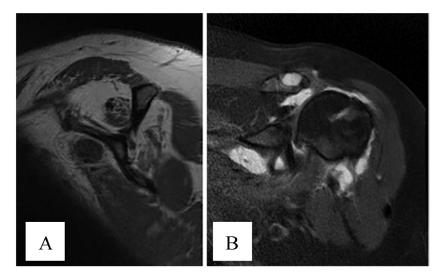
Left shoulder magnetic resonance images before superior capsular reconstruction: (A) sagittal T1 image demonstrates fatty infiltration and atrophy of the supraspinatus and infraspinatus and (B) axial T2 cut with previous implant and supraspinatus tendon retraction to the glenoid.
